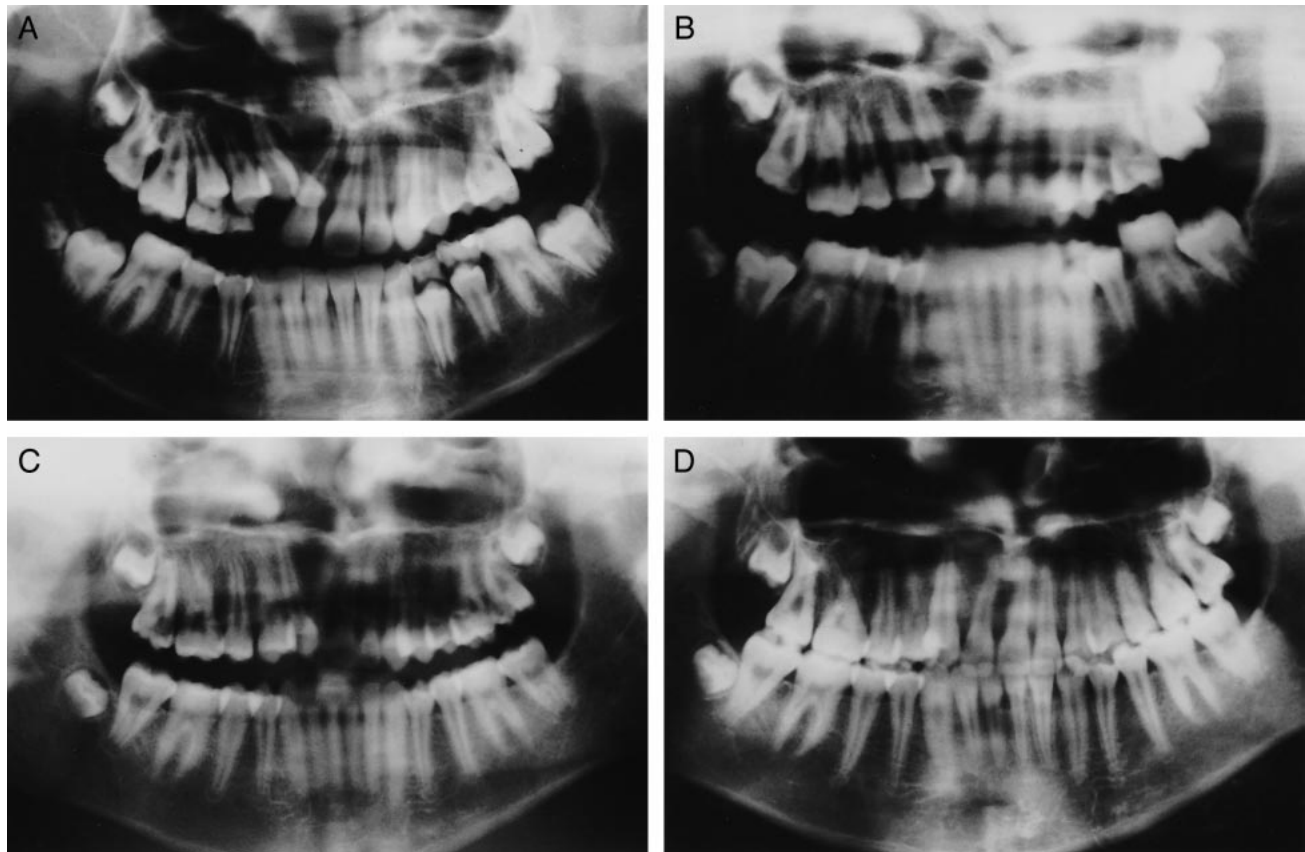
Panoramic radiographs. (A) One month before the secondary bone graft; (B) 3 months following the bone graft; (C) seventeen months after the bone graft; (D) 2 years and 4 months after the bone graft.
